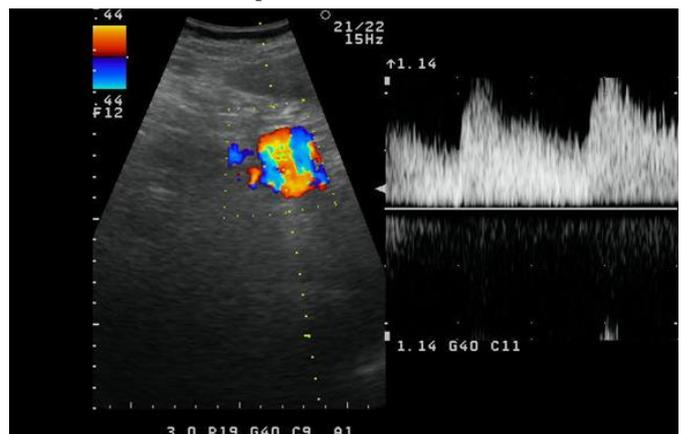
Colour Doppler ultrasound image showing splenic artery aneurysm along with its spectral waveform.
